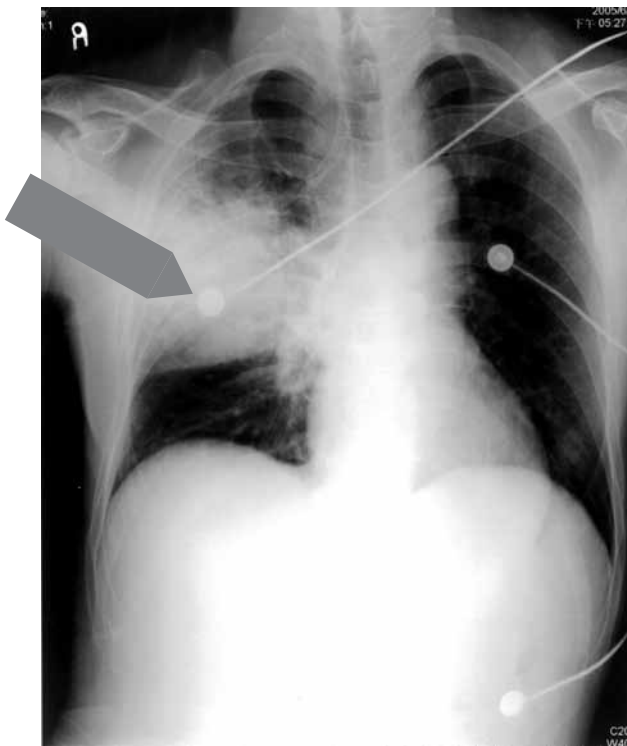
A: A chest X-ray on admission showed a pneumonic patch of the right middle lobe, bilateral interstitial infiltration, and pleural effusion.
